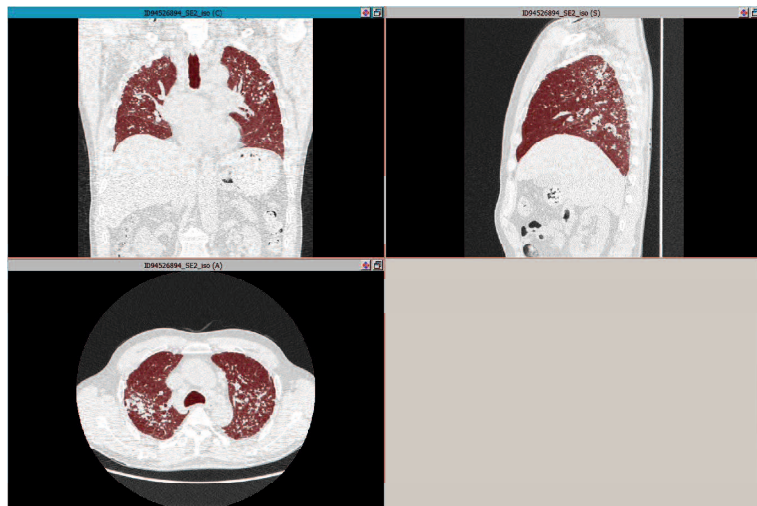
The three views of a HRCT image (axial, sagittal and coronal direction)
